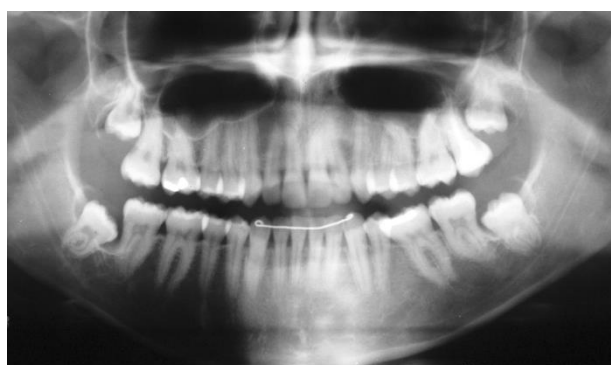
Initial panoramic radiograph showing radiolucent area around third molars.
